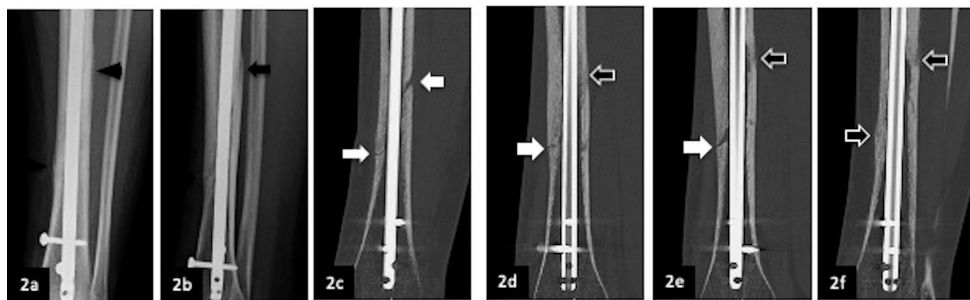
Left tibial fracture in a 46-year-old woman 121 days after fracture. (a,b) Antero-posterior and lateral radiographs demonstrated continuous remodelled callus (black arrowhead; score 4) at medial and lateral fracture edges and immature continuous callus (black arrow; score 3) at anterior and lateral fracture edges. RUS was 14. (c,d) Paramedian coronal and (e,f) sagittal CT reformats demonstrated no callus (white arrow; score 1), discontinuous callus (black arrow; score 2), continuous immature callus (white arrowhead; score 3) and continuous remodelled callus (black arrowhead; score 4). TUS was 8. In advanced healing, TUS is statistically significantly lower than RUS.
